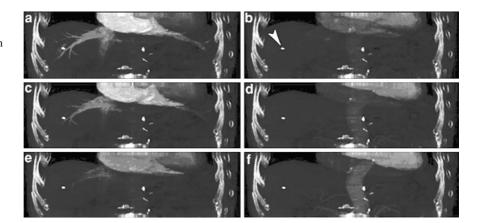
Dynamic CT scan of a patient with hepatocellular carcinoma using a CT-system with area detector. Coronal images with maximum intensity projection (MIP) beginning a 30 s, b 31.0 s, c 33.1 s, d 34.5 s, e 37.4 s, f 39.4 s after contrast injection (from Mori et al. (2006c))
